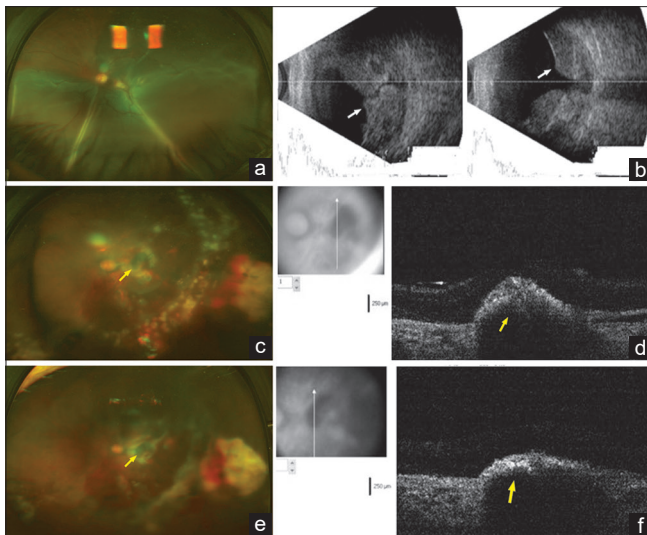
Preoperative optos (a) and B-scan ultrasonography (b) showing hemorrhagic retinal detachment (white arrows) with vitreous hemorrhage in case 5. Postoperative submacular autologous RPE-choroid graft with a gradual decrease in graft edema in serial OCTs (yellow arrows) at 2 weeks (c and d) and 4 weeks (e and f)
